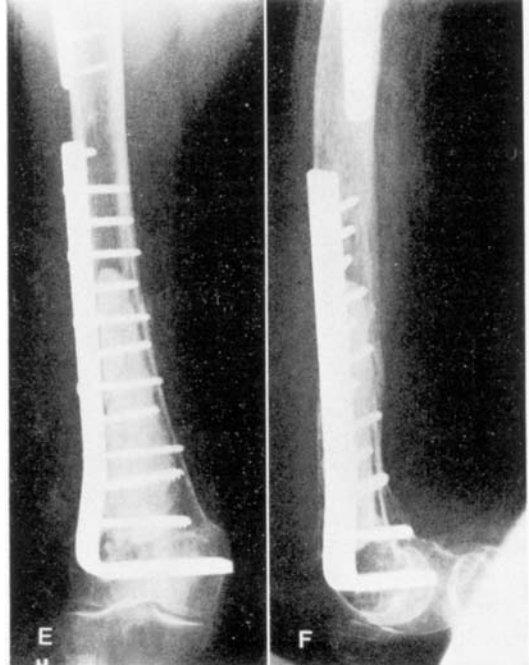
E. and F. Radiographs 3 months after operation. The lateral view reveals that the fracture has been bridged by bone posteriorly. There is no abundant periosteal callus formation. No signs of loosening of the screws are seen. The axes are unchanged from the first operative examination (compare with Figure 1. C. and D.).
